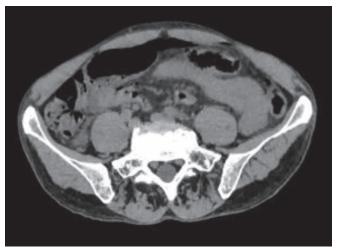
Pneumoperitoneum in simple abdominal CT
